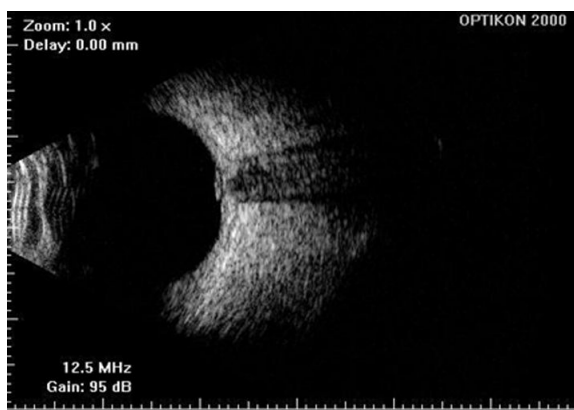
Ultrasound of the right eye showing the optic disc swelling.
